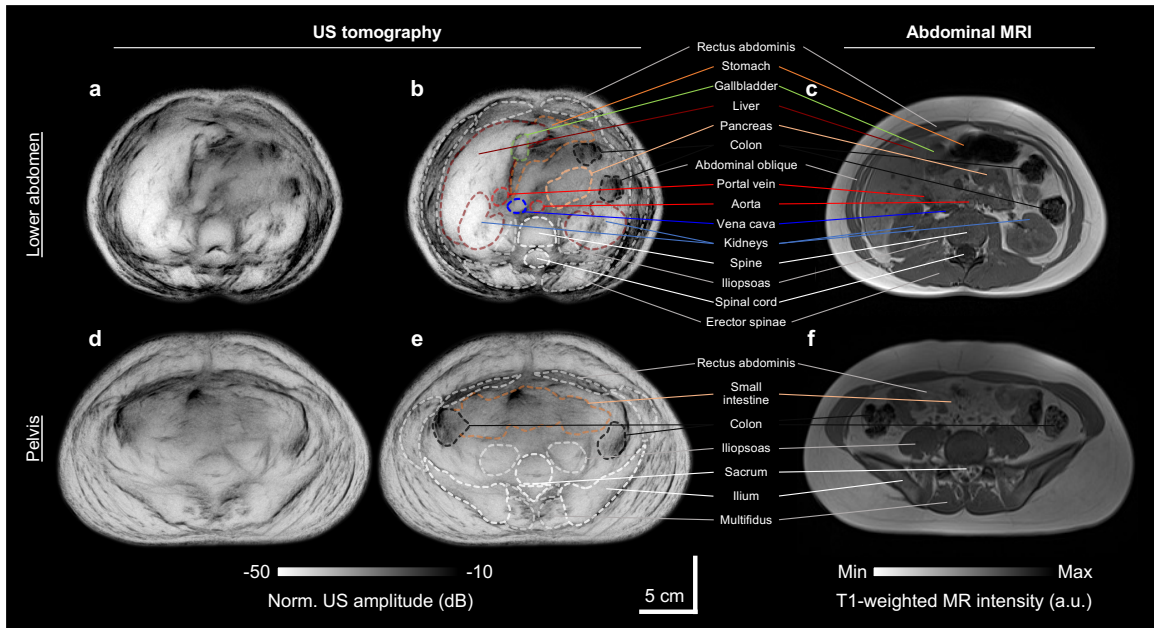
Example reflection-mode UST images of a healthy female’s abdomen (Subject 1) compared with T1-weighted MRI. a, Unlabeled reflection-mode UST image 6 cm inferior to the starting position. b, Labeled UST image identifying various organs and structures. c, T1-weighted MRI image of a corresponding region. d, Unlabeled UST image 15 cm inferior to the starting position. e, Labeled UST image. f, MRI image of a corresponding region.
